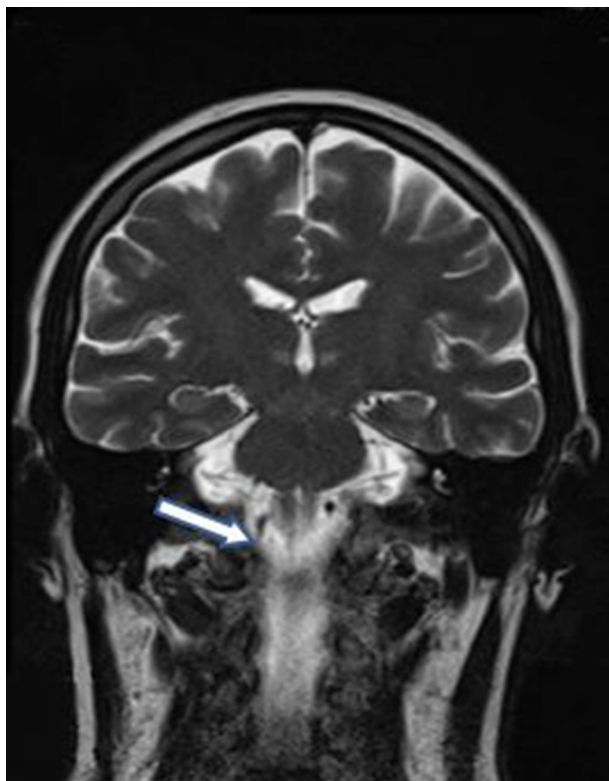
MRI (Coronal T2 Weighted Sequence) Consistent With the Diagnosis of WE
